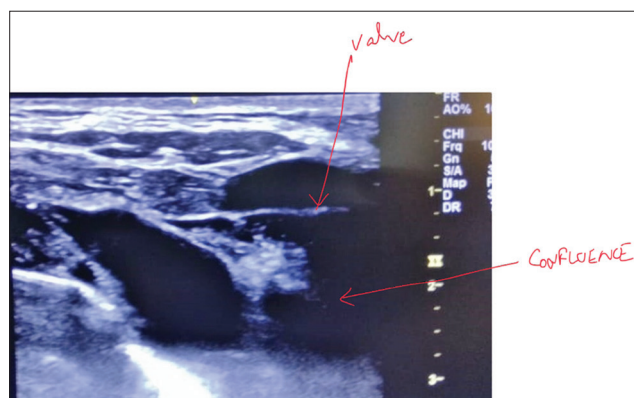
Ultrasonographic image of the confluence of subclavian vein and brachiocephalic vein as labeled. Along with valve seen at junction of subclavian vein and brachiocephalic vein
